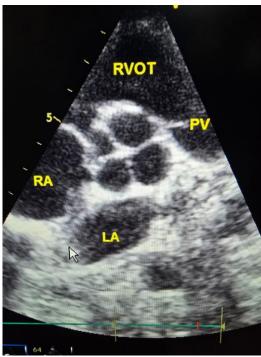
Parasternal short-axis echocardiographic view demonstrating a quadricuspid aortic valve (QAV) with one small cusp, one large cusp, and two intermediate cusps, corresponding to Hurwitz and Roberts' Type D classification
